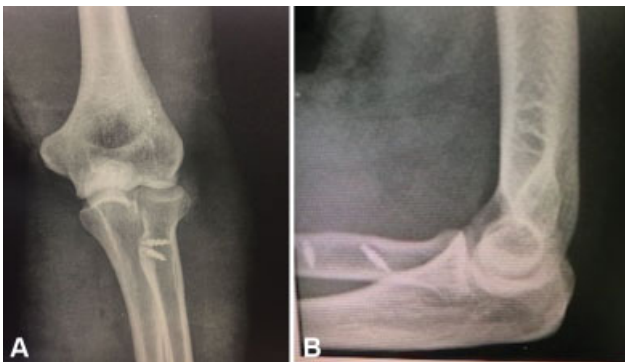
Case 7, 40-year-old male patient. Postoperative radiography. (A) Anteroposterior view; (B) lateral view.
